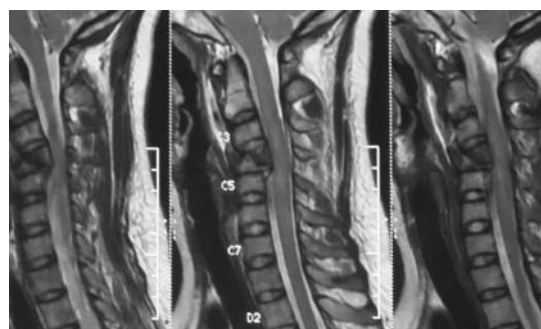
Sagittal MRI section showing cord compression and changes in cord.
